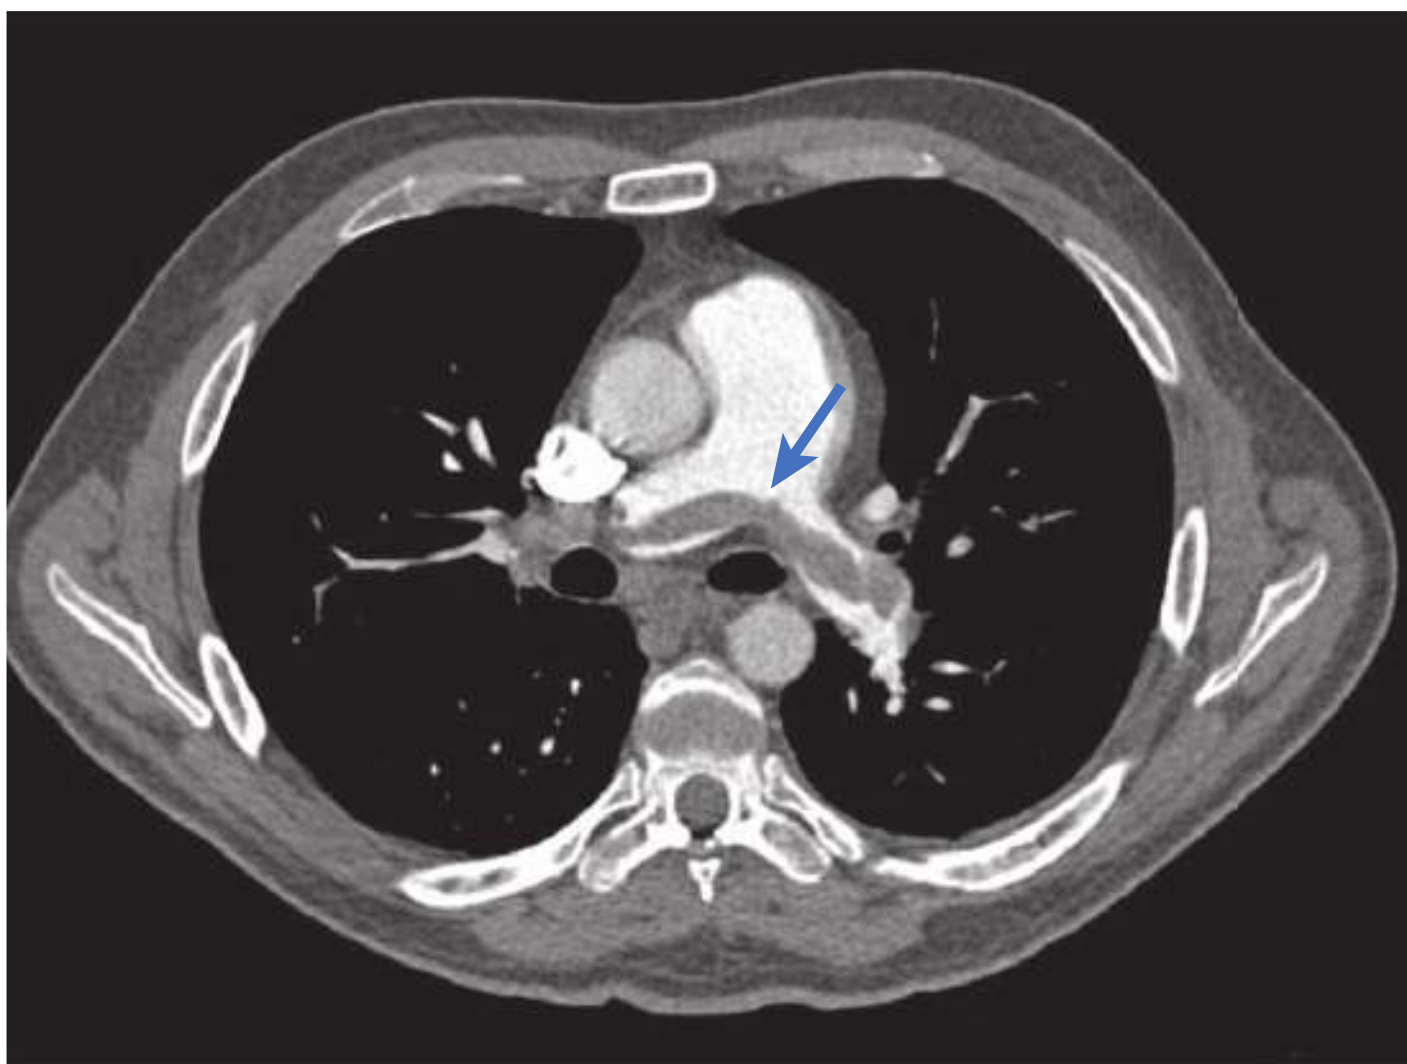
CT angiogram displaying a massive pulmonary embolism. There is a large filling defect in the main pulmonary artery that extends into branches of both left and right pulmonary arteries (blue arrow). (Courtesy of Andetta Hunsaker MD, Brigham and Women's Hospital, Boston, MA.)
